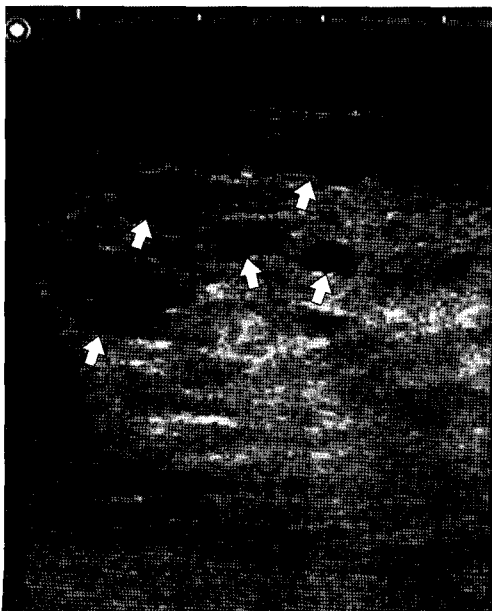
Sagittal ultrasonographic image of the abdominal mass. Note the presence of multiple anechoic lesions (arrows) in a solid mass.
